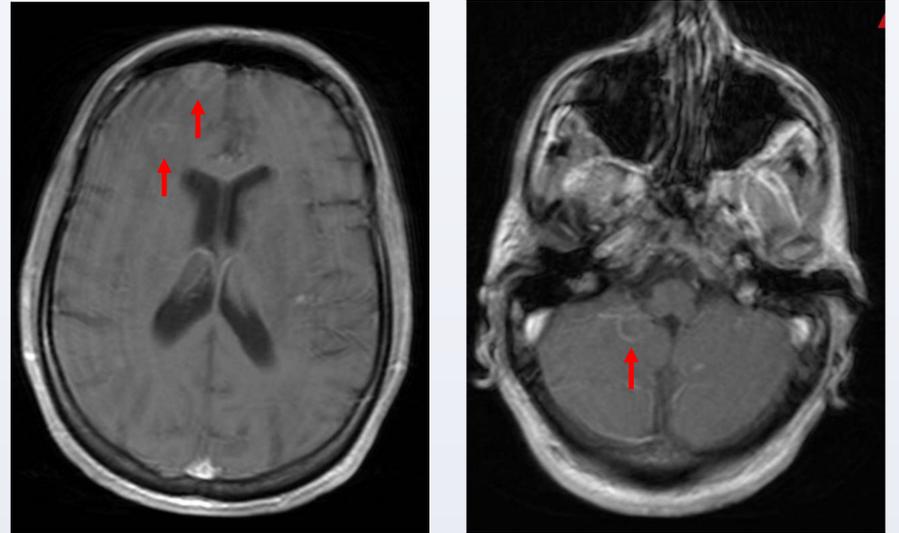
A (left) and B (right): Axial post-contrast MRI demonstrates multiple, bilateral ring-enhancing lesions (red arrows).
